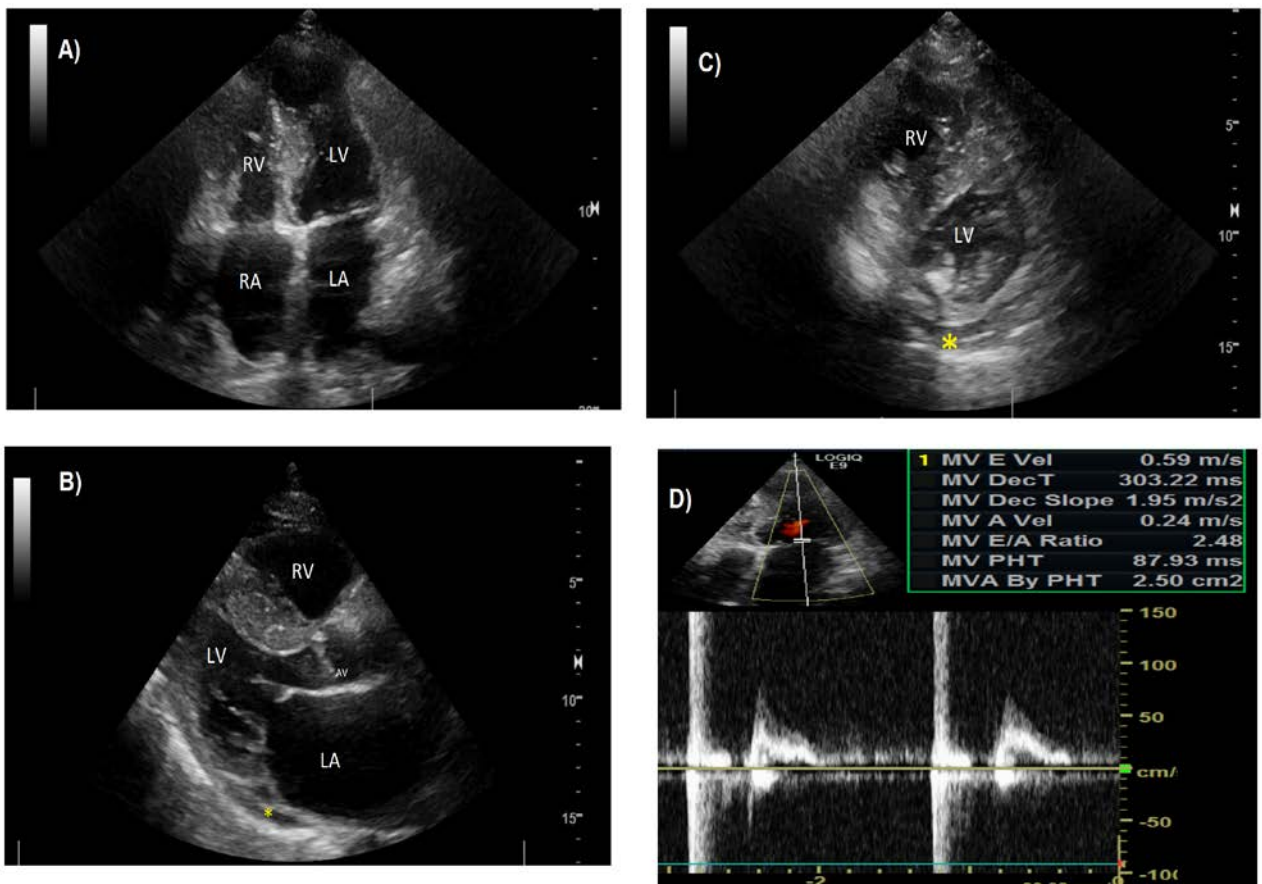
Transthoracic echocardiography showing A) Four chamber echocardiographic view demonstrating bi atrial enlargement, left ventricular hypertrophy, small pericardial effusion, B) Short axis echocardiographic view demonstrating severe concentric left ventricular hypertrophy with small pericardial effusion (*), C) Parasternal long axis echocardiographic view demonstrating severe concentric left ventricular hypertrophy with small pericardial effusion (*), D) Doppler demonstrating restrictive physiology with an E velocity of 0.59 cm/s and E/A 2.48, and her E' velocity of 2.78 cm/s and E/med E' 18.75
